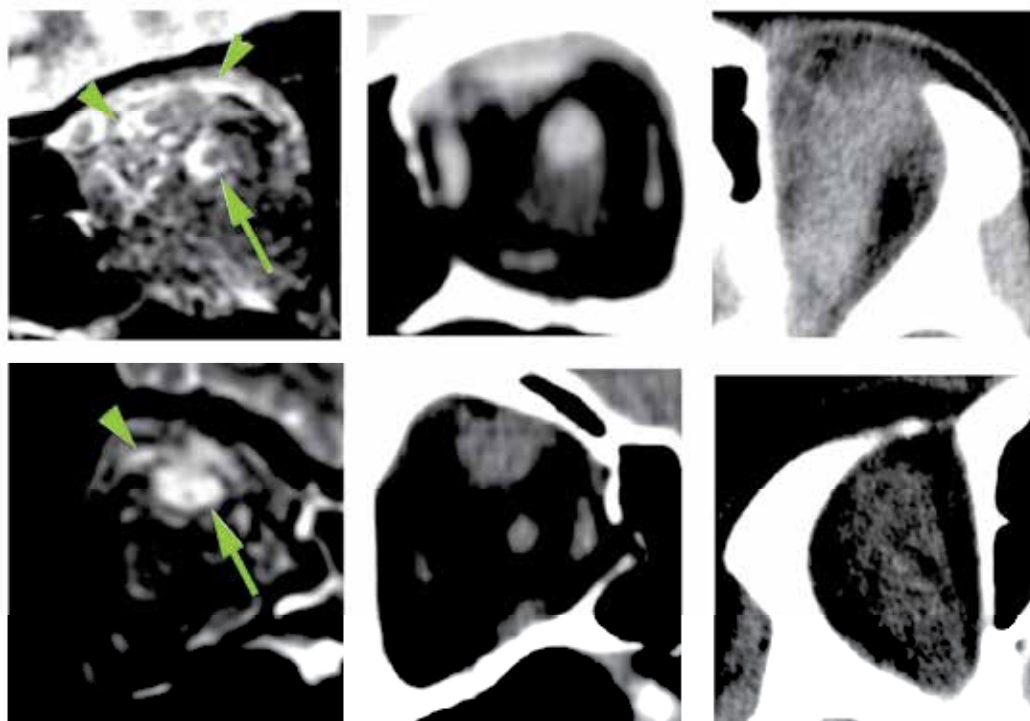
Fat-suppressed T2-weighted MR image and coronal (middle) and axial (right) CT images recorded at the same time in a patient with idiopathic orbital myositis in the active phase. Top: Acute type of idiopathic orbital myositis. Fat-suppressed T2-weighted MR image shows a hyperintense signal in the fascicle structure (arrowhead) around the superior rectus muscle, and indistinct swelling around the superior rectus muscle in the CT image (Top center). An arrow points to the optic nerve for comparison to coronal CT scan at the posterior pole. Bottom: Chronic type of idiopathic orbital myositis. Fat-suppressed T2-weighted MR image shows a hyperintense signal of the superior rectus muscle (arrow) and the adjacent structures (arrowhead). Reproduced with permission from Kubota, T. & Kano, H. (2007) Assessment of inflammation in idiopathic orbital myositis with fat-suppressed T2-weighted magnetic resonance imaging. *American Journal of Ophthalmology*, Vol.143, No. 4, pp.718-720, ISSN:0002-9394
